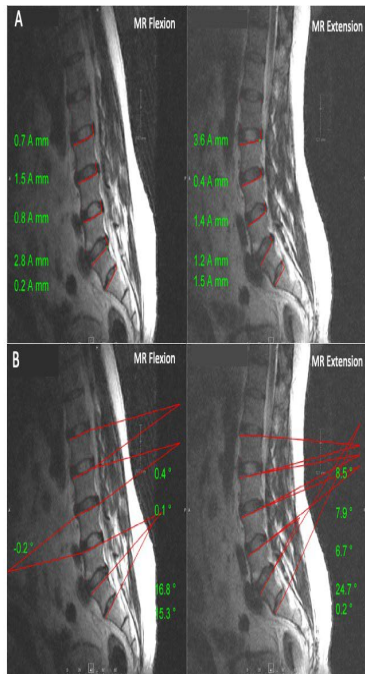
T2-weighted mid-sagittal MRI images in both lumbar flexion and extension positions with anteroposterior (AP) vertebral translation measurements in Figure 1A, and intervertebral angulation measurements in Figure 1B.
